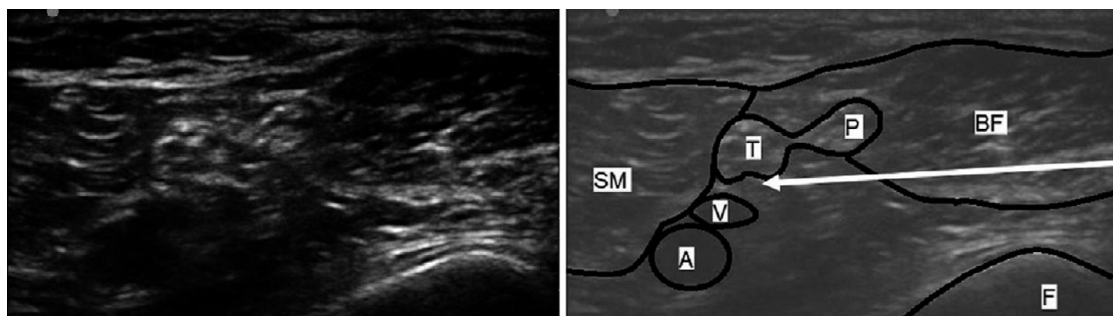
Ultrasound appearance of the popliteal fossa showing semimembranosus muscle (SM), biceps femoris (BF), tibial (T) and popliteal (P) nerves, popliteal artery (A) and vein (V) and the femur (F).
